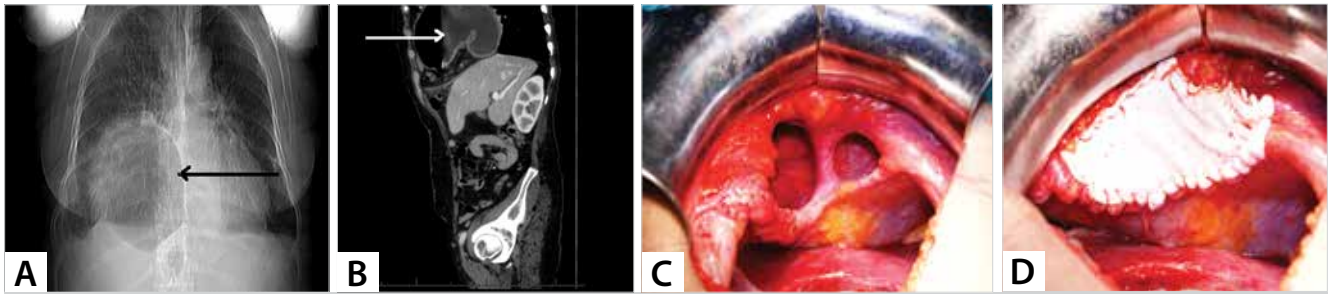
A. Right paracardiac opacity in chest x-ray. B. Herniated stomach in left Morgagni hernia sac. C. Bilateral Morgagni defects. D. Repair with ePTFE mesh.
